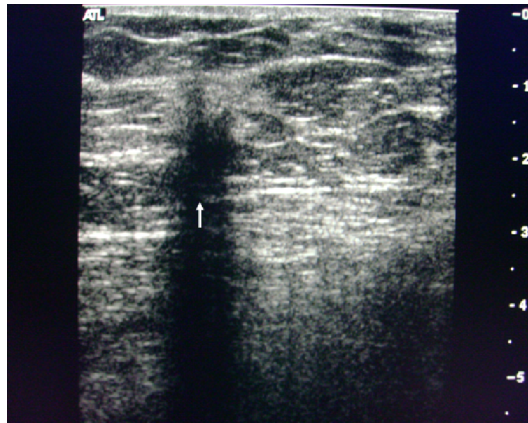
Ultrasound of the right breast. White arrow indicates lesion.
